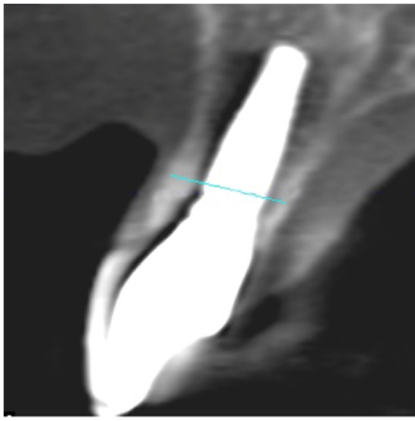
Measurement of hard tissue dimension 3 mm apical to the bone crest. The measurement was performed using cone beam tomography 3 mm apical to the bone crest. Solid light blue line represents the distance between the buccal and lingual bone surface
